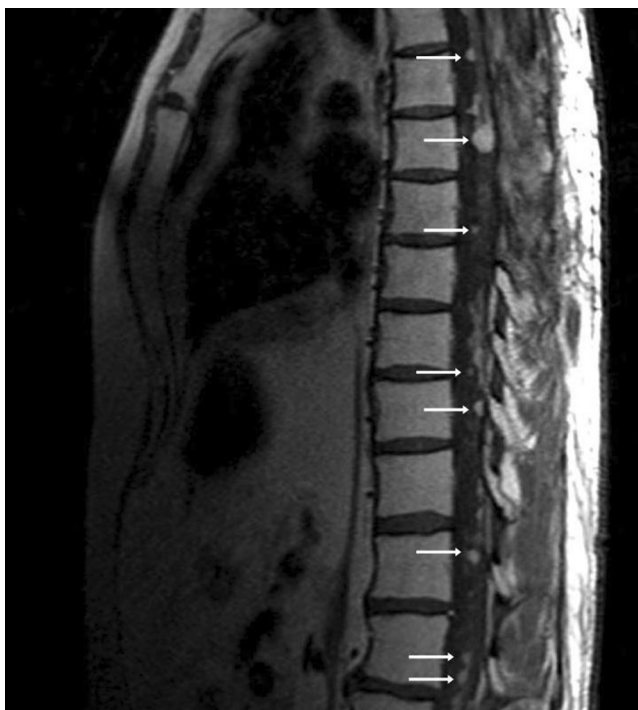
Transversal T1-weighted MRI showing hyperintense, contrast-enhancing, intradural metastases in the thoracic spinal canal
